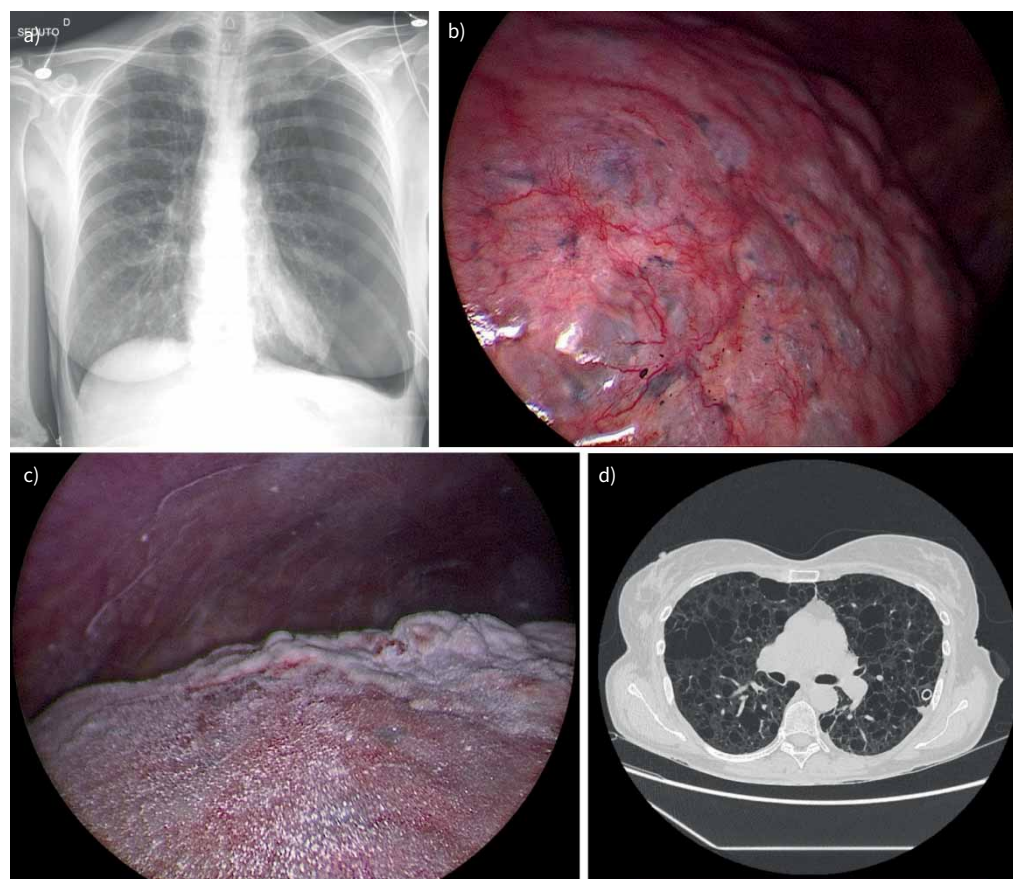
Case of secondary spontaneous pneumothorax in a patient suffering from lymphangioleiomyomatosis managed by medical thoracoscopy and talc poudrage. a) Chest radiograph at diagnosis showing a massive left pneumothorax. b) Direct endoscopic view of the pleural cavity and visceral pleura with subpleural cystic lesions. c) Deposition of sterile talc at the end of the insufflation. d) Final computed tomography result with chest drain clamped in place showing complete lung expansion and achievement of pleurodesis.
